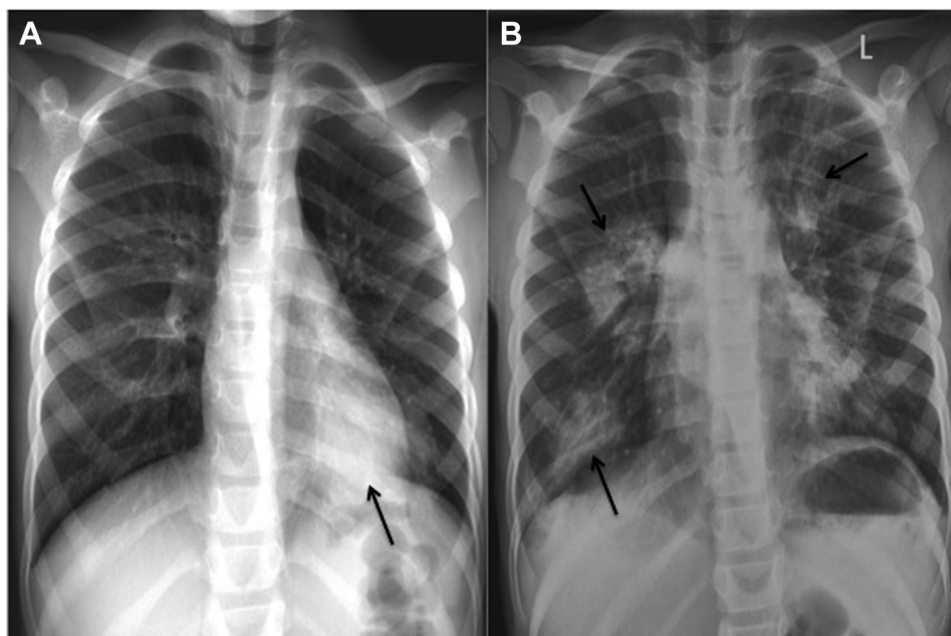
(A) Chest X-ray at presentation demonstrating left lower lobe retro-cardiac consolidation (arrow). (B) Chest X-ray 1 month later demonstrating multiple focal lung consolidations in the right and left lobes (arrow), disappearance of the retro-cardiac consolidation.
